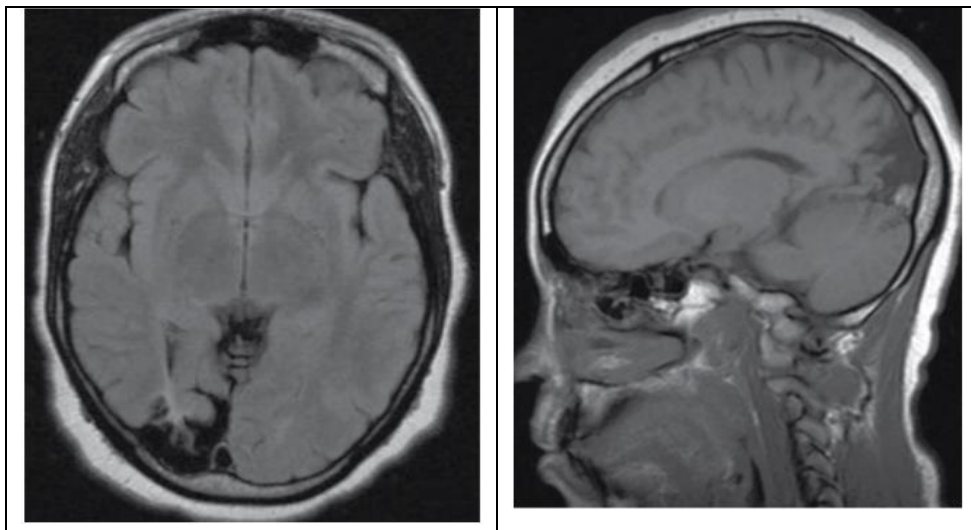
Right cortico-subcortical parietooccipital lesion of encephalomalacia on axial (a) and parasagittal (b) planes of MRI.
